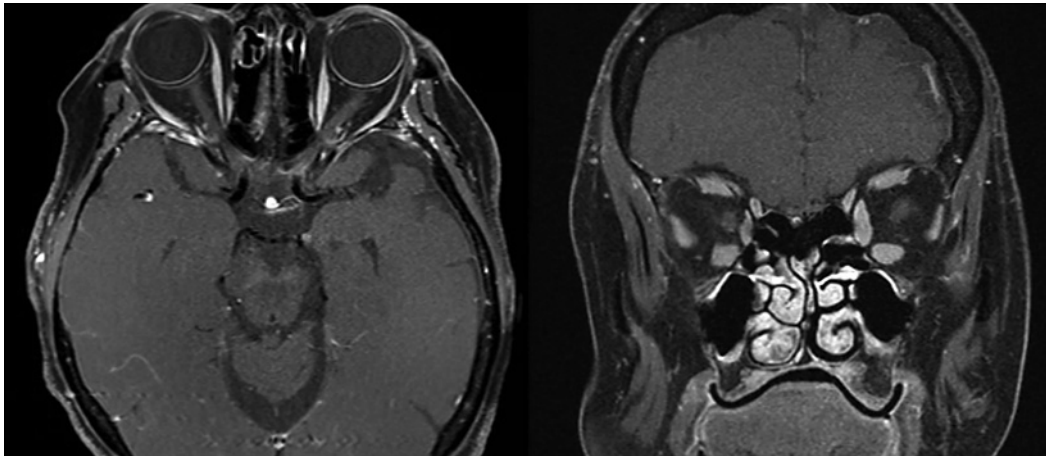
3T orbital MRI with contrast of a 67-year-old woman 5 days after vision loss from right MOG-IgG-ON which showed no optic nerve enhancement.
